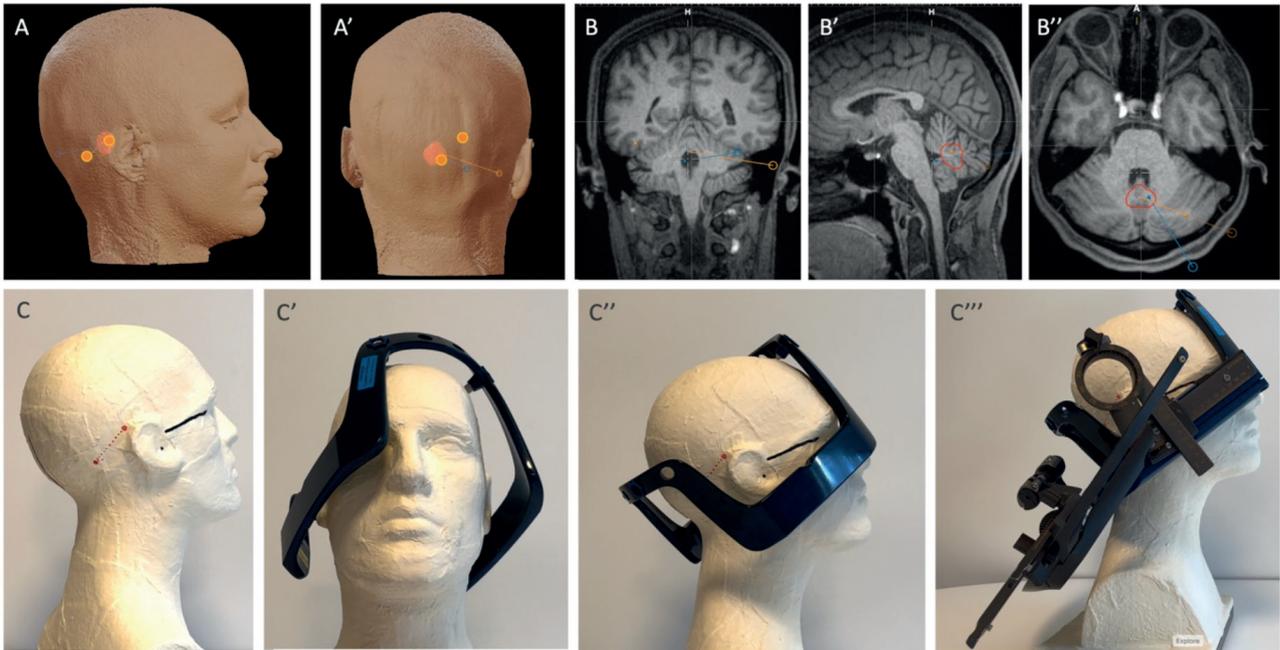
Example of very lateral entry point and steep trajectory that necessitate extreme axial and sagittal frame angles. A, A': using landmarks from 3D model of software. B, B', B'': using landmarks from raw MRI images to transfer target and entry (red circles) on patient (C). Frame placement with extreme axial (C') and sagittal rotation (C''). C''': with arc system attached.
